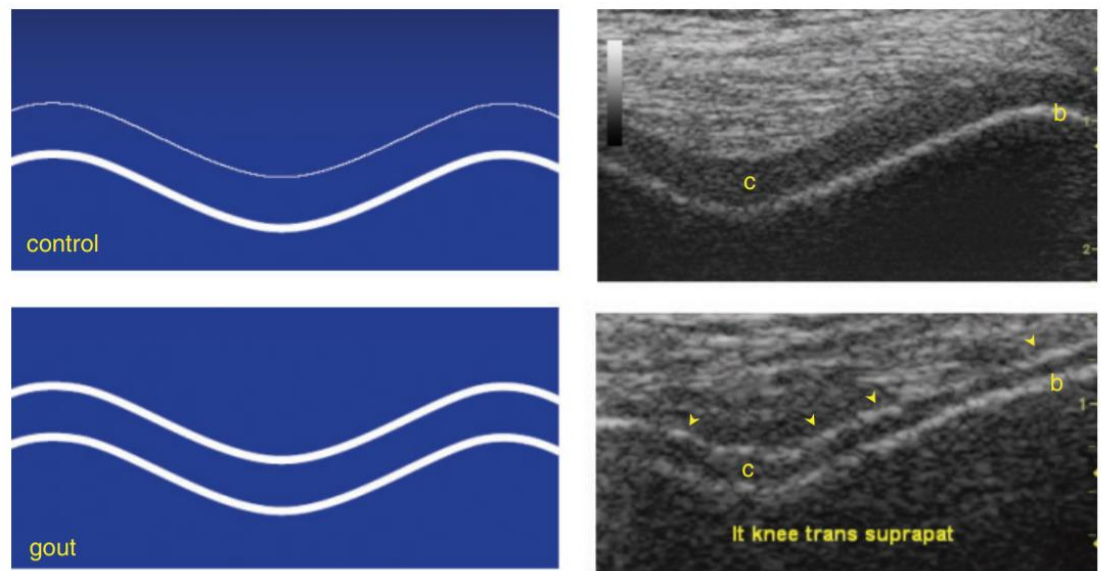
Comparison of ultrasound images of healthy vs gouty knee joints showing the double contour sign.
